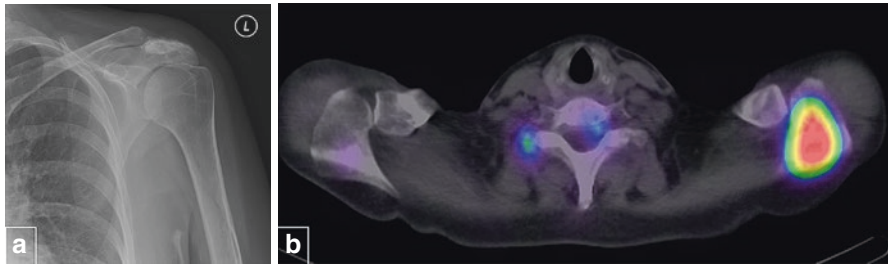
AP radiograph (a) of the left shoulder demonstrating a sclerotic focus in the acromion in a patient with a history of previous breast cancer. This demonstrated intense FDG uptake on the PET-CT (b). Biopsy confirmed sclerotic bone metastases
